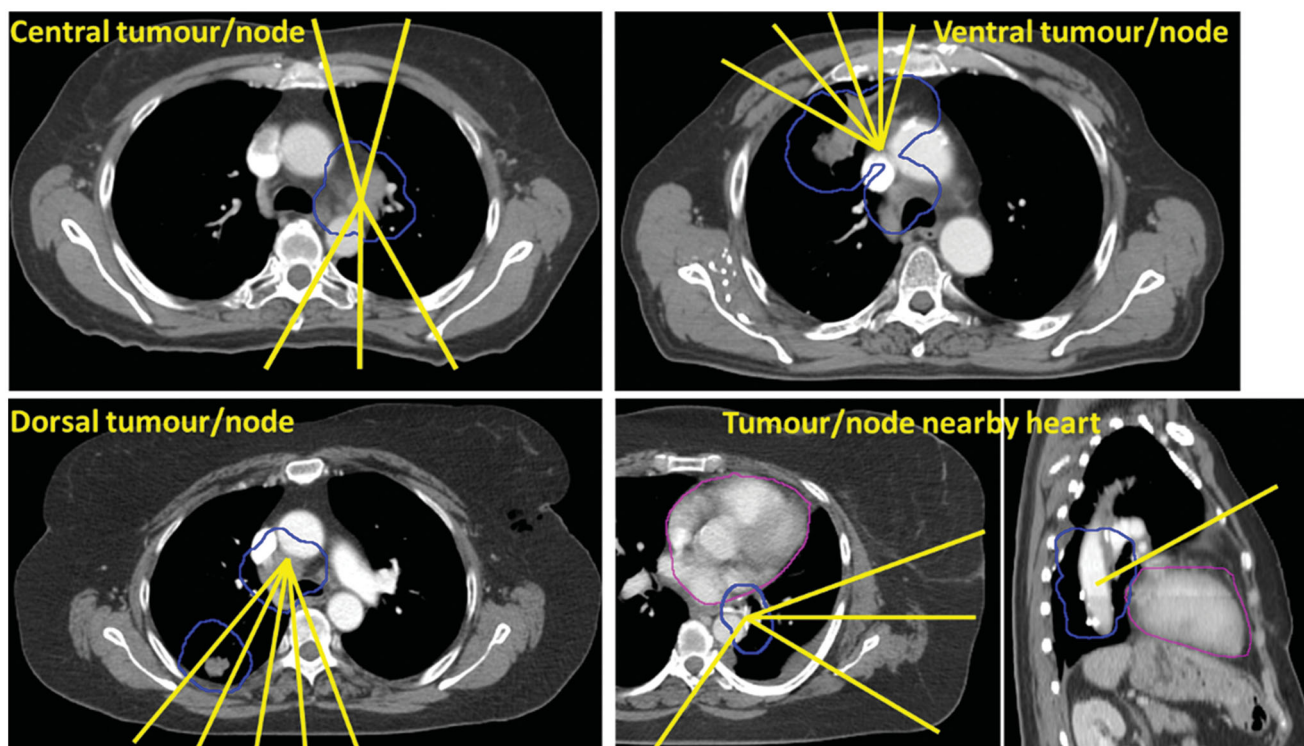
Examples of beam angle selection (lines) depending on tumor/node location. The beam angles were set individually for all target locations, depending on the actual position of tumor and lymph nodes. PTV is outlined in all CT slices.
